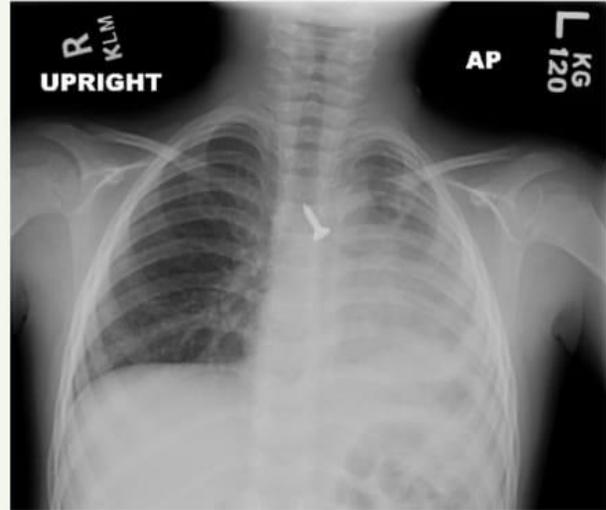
Upright AP Chest radiograph demonstrating a foreign body at the level of the carina
